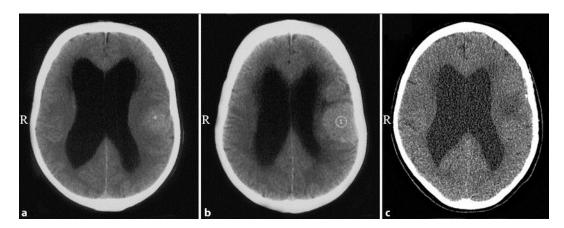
Neuroimaging of case 1. CT scans before the surgical intervention (a, b) and 1 month later (c).
